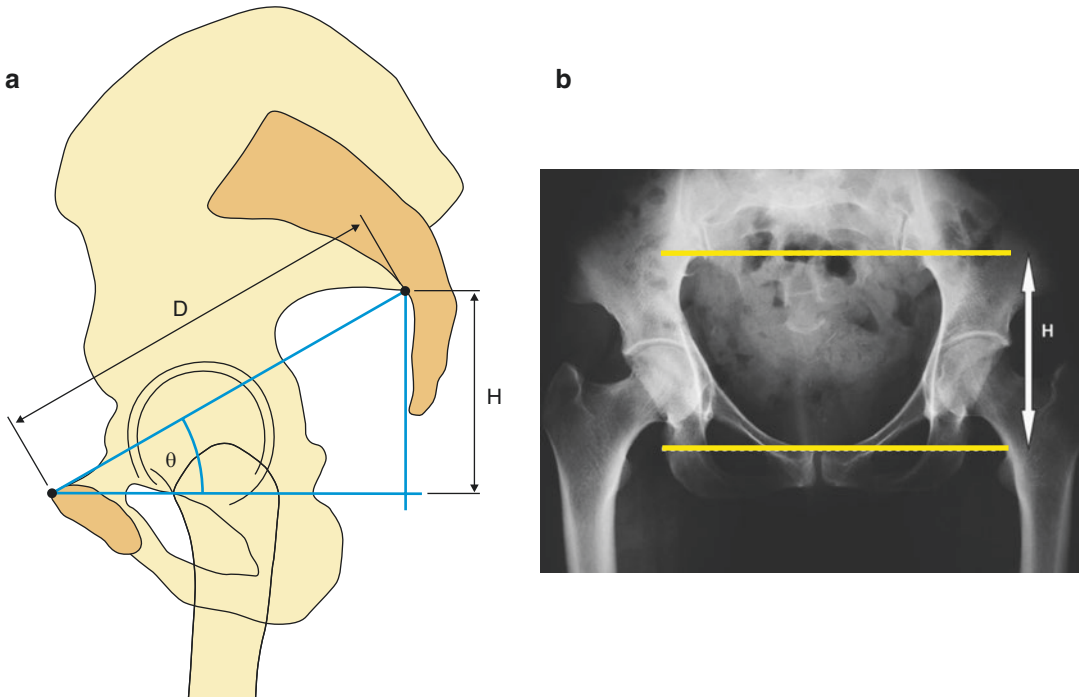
Pelvic inclination formula to assess pelvic tilt from AP radiograph
